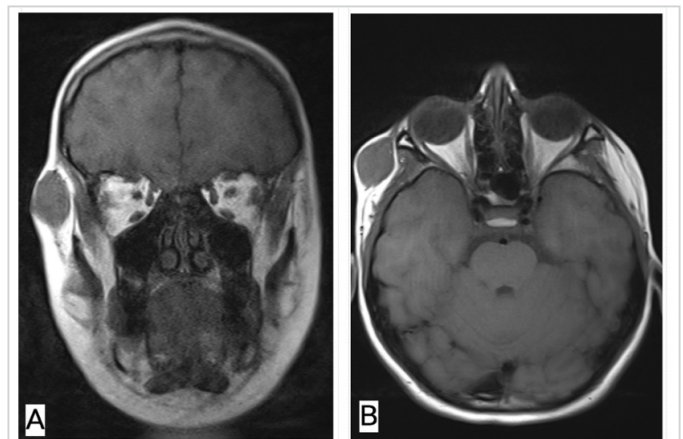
Preoperative magnetic resonance imaging of a schwannoma in the right temporoorbital region, demonstrating a well-defined 32×16×26 mm mass with low signal intensity on T1-weighted sequences A) coronal view B) axial view
